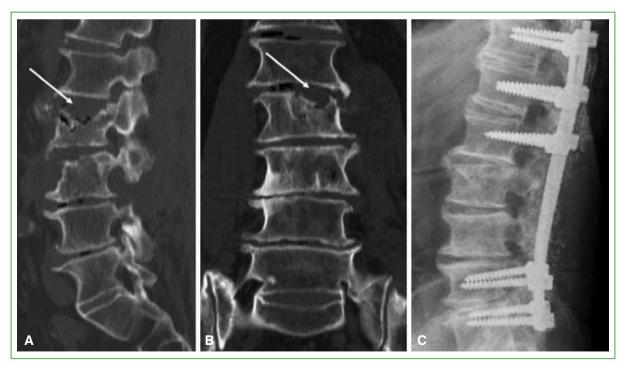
Lumbar spine CT. A. Sagittal section. Osteolytic lesions in L3 and L4 upper plates and bodies. B. Frontal section. Osteolytic lesions in L3 and L4 upper plates and bodies. C. Lumbar spine X-ray. Sagittal section showing the result of the T12-L1-L2-L5 and S1 long lumbar fixation (November 2012).
